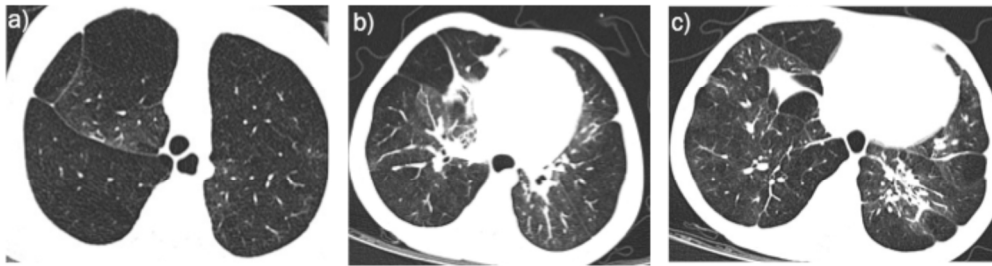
Axial chest computed tomography images of case 4 of the (a) upper lobes and (b and c) lung bases reveal marked overinflation of both upper lobes and the right middle lobe with bilateral lower lobe atelectasis
